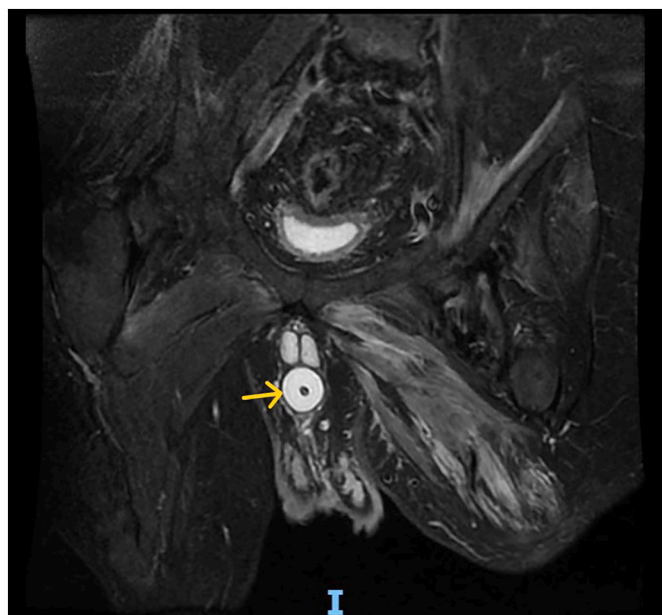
MRI of pelvis - T-2 weighted image (coronal view) in the same patient as Fig. 8, shows the Foley balloon filled with water as a bright circle in the penile urethra (arrow).
